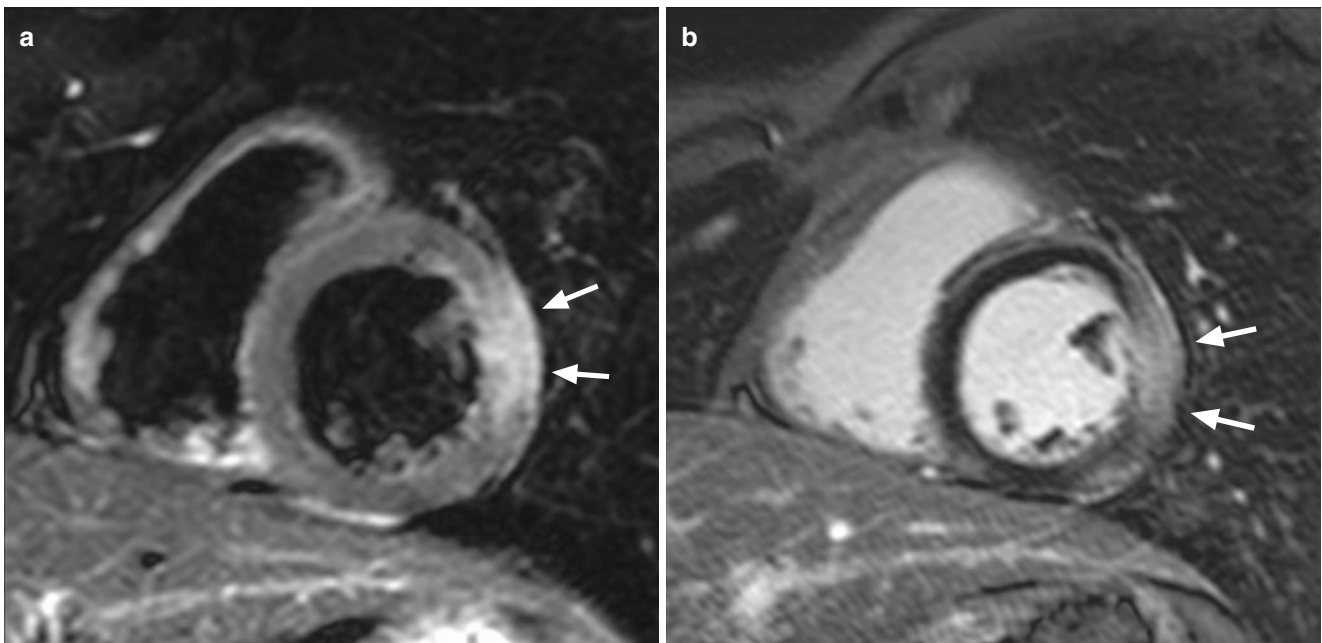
MRI of a patient with acute myocarditis. (a) Short-axis T2-weighted image shows myocardial edema in the lateral wall of the left ventricle. (b) Short-axis late gadolinium enhancement image reveals transmural enhancement along the lateral wall of the left ventricle
